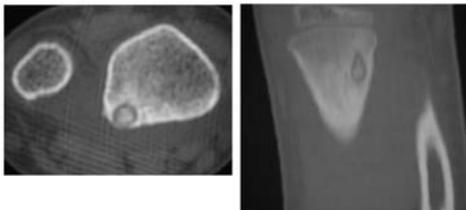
and 10 Axial CT and coronal reformat CT slices.
